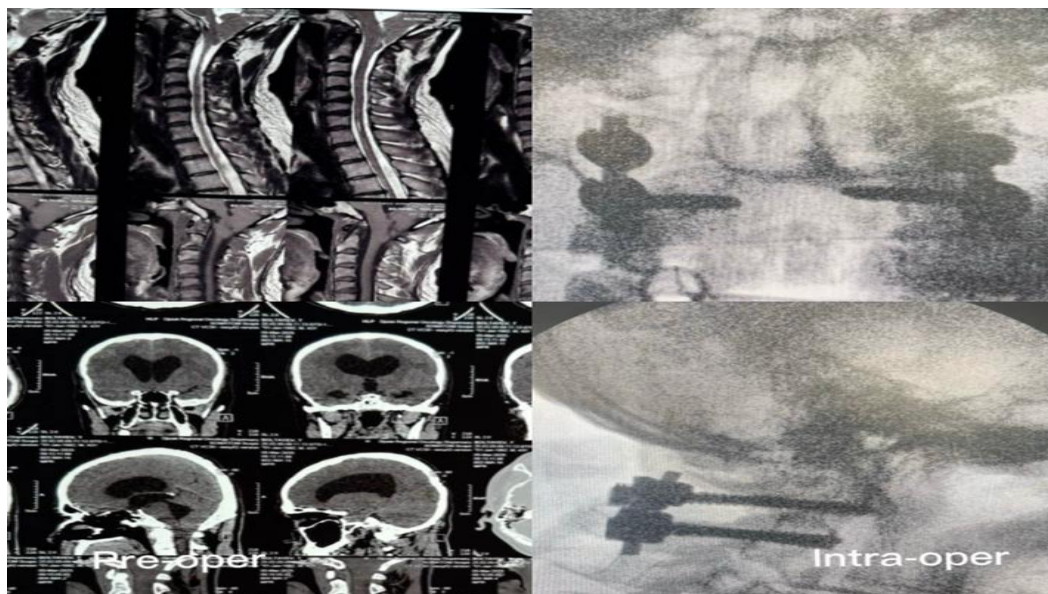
Postoperative radiograph showing posterior C1-C2 stabilization with bony-dural decompression
